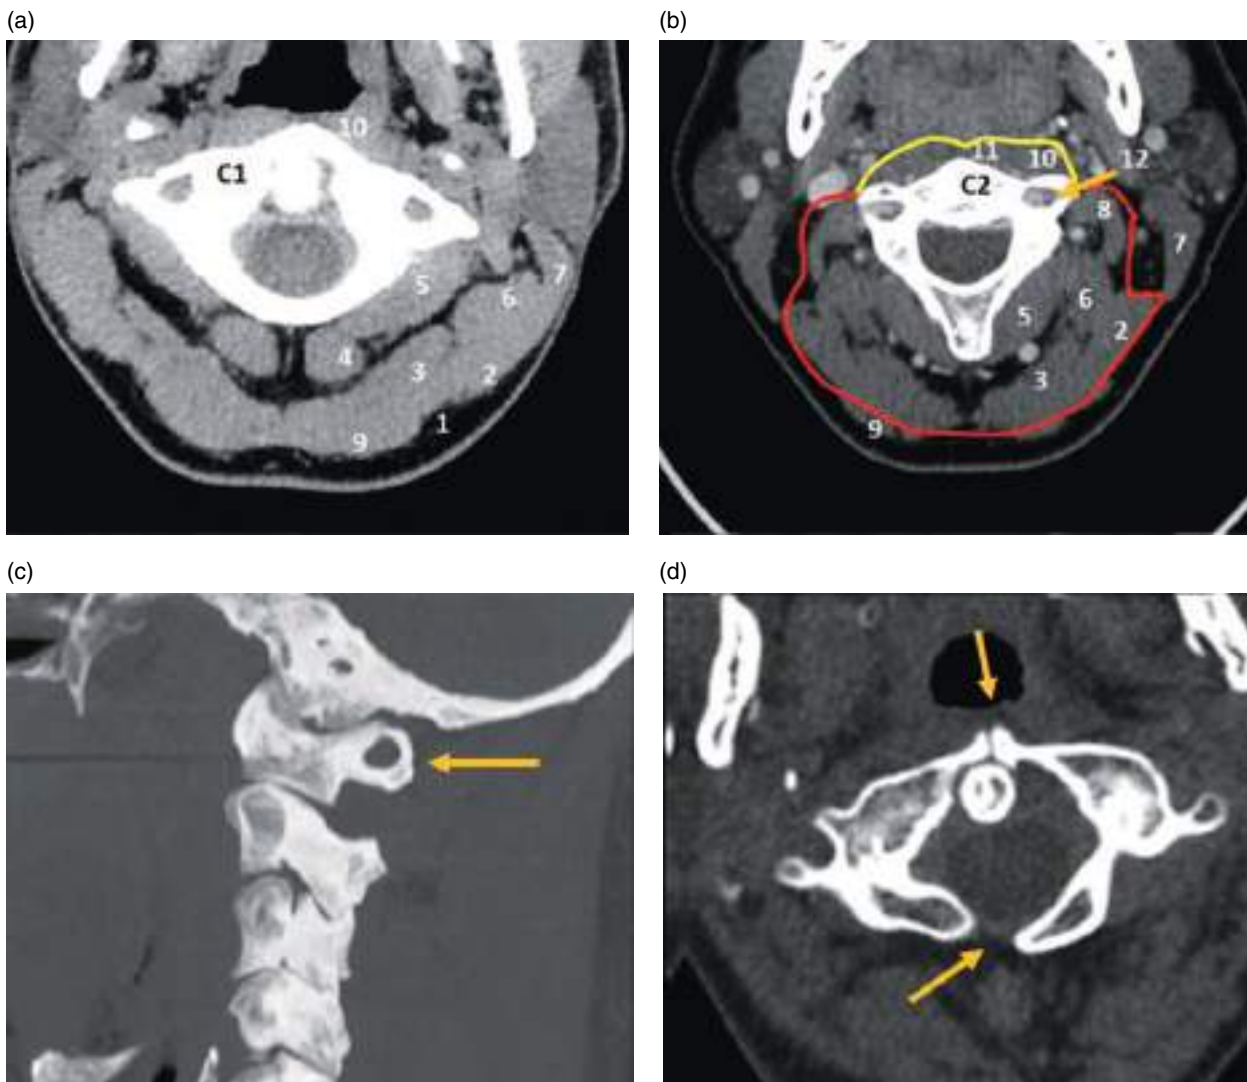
Axial CT image at the level of the atlas (a) and axis (b). (c) Arcuate foramen of the atlas (Kimmerle anomaly) (arrow). (d) Split atlas (arrows). 1, cervical fascia, superficial layer; 2, splenius capitis muscle; 3, semispinalis capitis muscle; 4, rectus capitis posterior major muscle; 5, obliquus capitis inferior muscle; 6, longuissimus capitis muscle; 7, sternocleidomastoid muscle; 8, levator scapulae muscle; 9, trapezius muscle; 10, longus capitis muscle; 11, longus colli muscle; 12, vertebral artery. The perivertebral space is subdivided into prevertebral (yellow) and posterior paraspinous (red) spaces.
